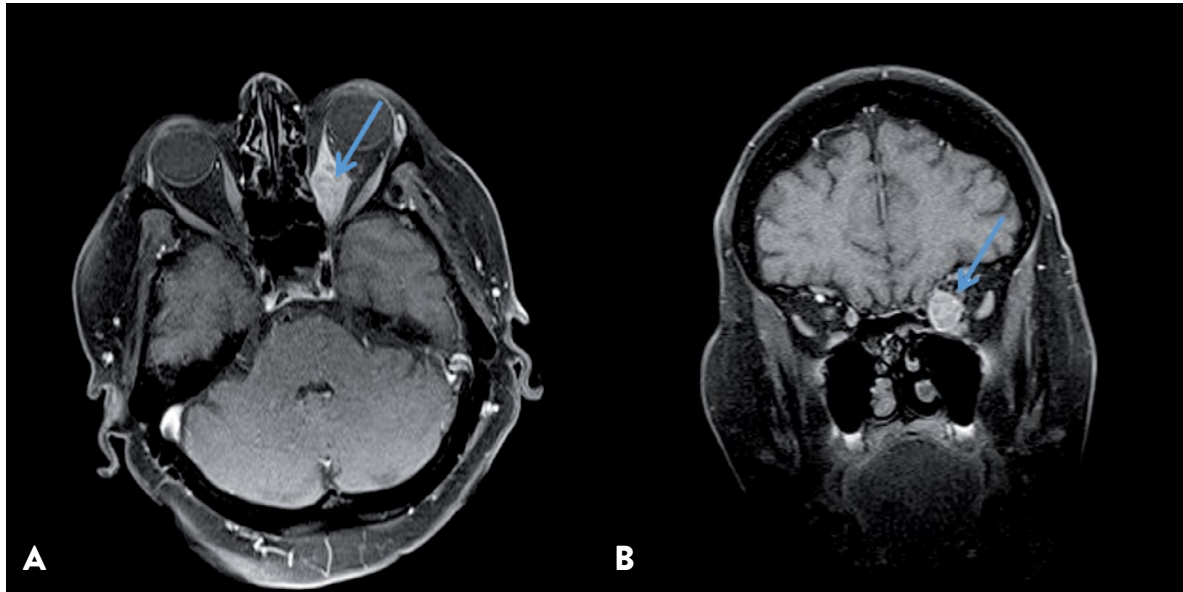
Retrobulbar formation in the left orbit with signal hyperintensity on MRI postcontrast T1-weighted images: (a) axial plane; (b) coronal plane.
